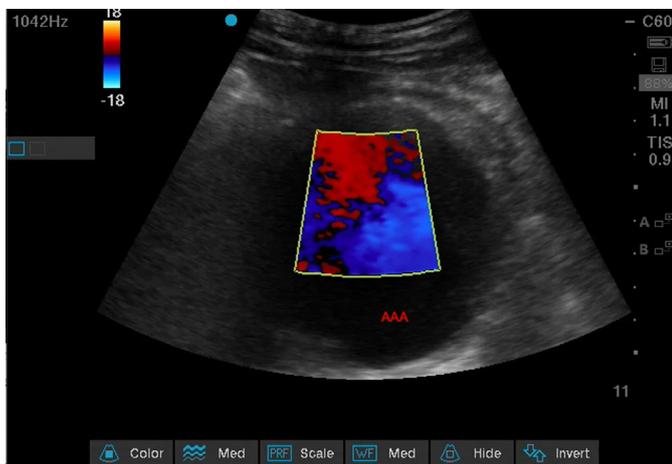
Transverse sonogram with color Doppler of the abdominal aorta demonstrating abdominal aortic aneurysm. AAA: abdominal aortic aneurysm.
